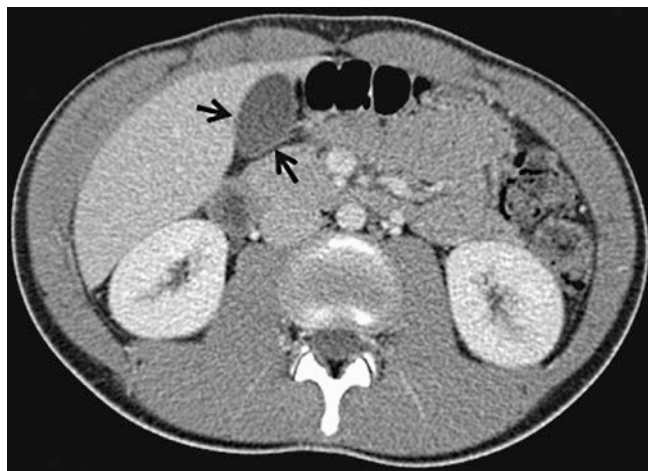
Axial CT of a normal thin-walled gallbladder
